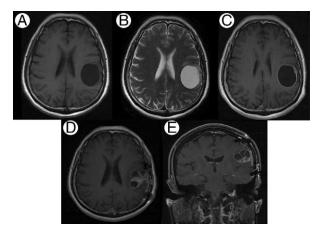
The MRI of the preoperative and recurrent tumor. A, T1-weighted axial MR image shows a cyst in the temporoparietal lobe. B, T2-weighted axial MR image shows a cyst in the temporoparietal lobe. C, After Gadolinium administration, T1-weighted axial MR image shows enhancement of the cyst wall. D-E, 6 months later, Gadolinium-enhanced axial and coronal T1-weighted MR image shows the recurrence of the tumor. MR, magnetic resonance.
